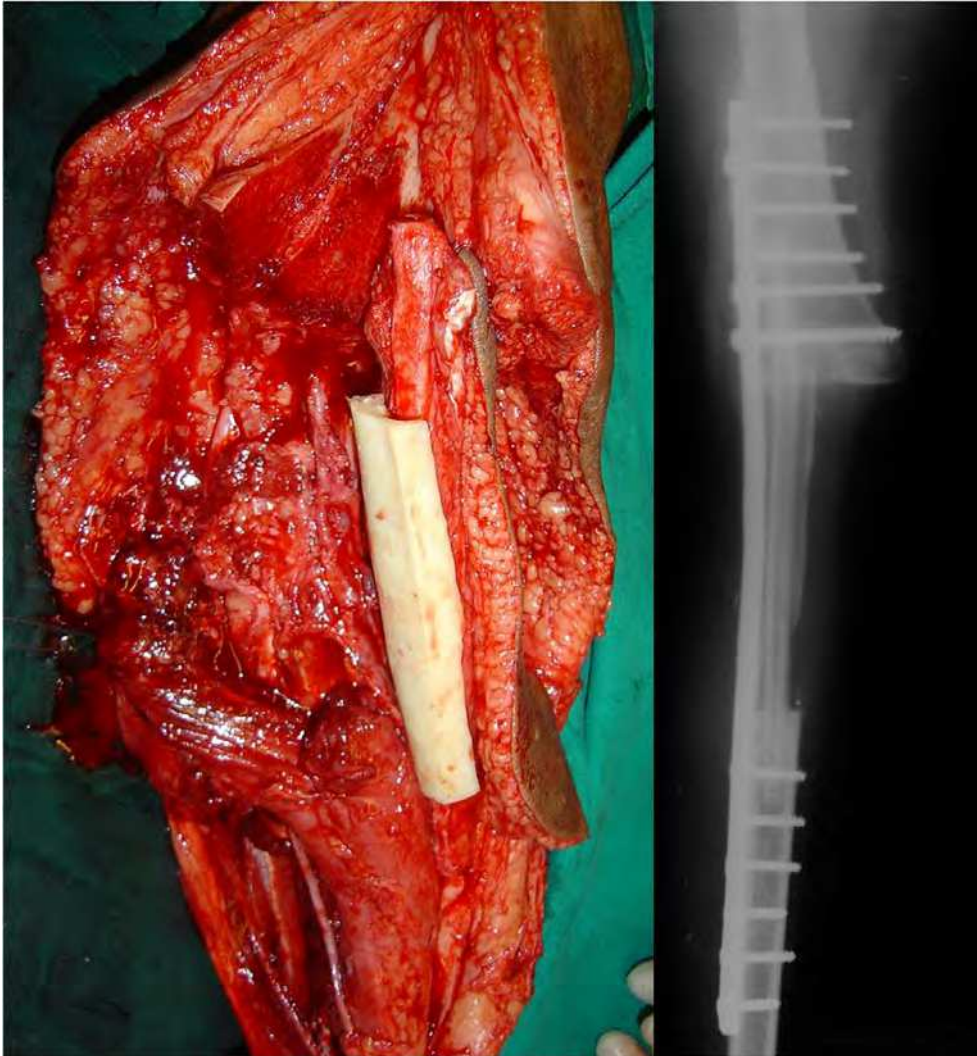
An allograft with a pedicled (vascularised) fibula for a resection arthrodesis of the knee. The allograft is hemicylindrical to avoid any compression of the pedicle or skin attached to the fibula. The xray shows the union at junctions which happened uneventfully in less than 6 months.
